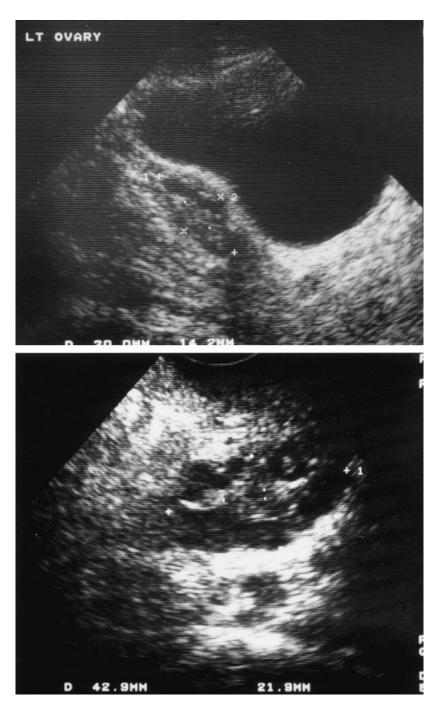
The ultrasound appearance of postmenopausal polycystic ovaries.
